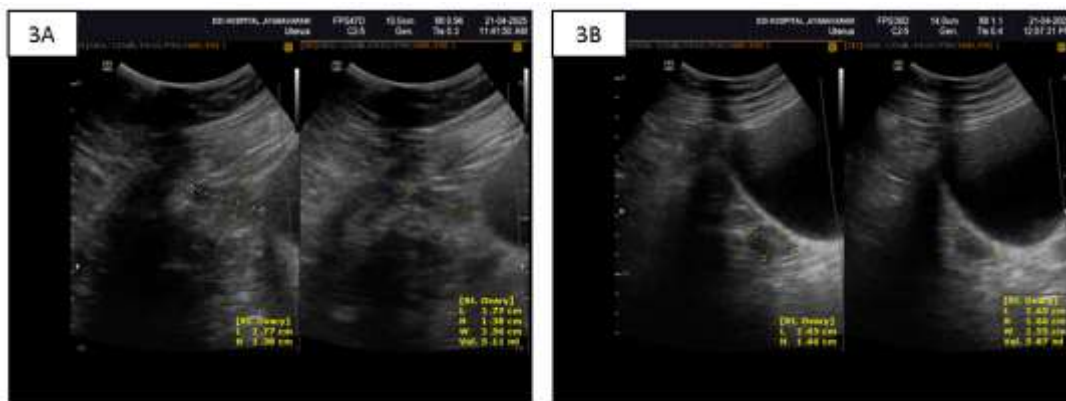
Right ovary ultrasound (Pre) Ayurvedha treatment.
